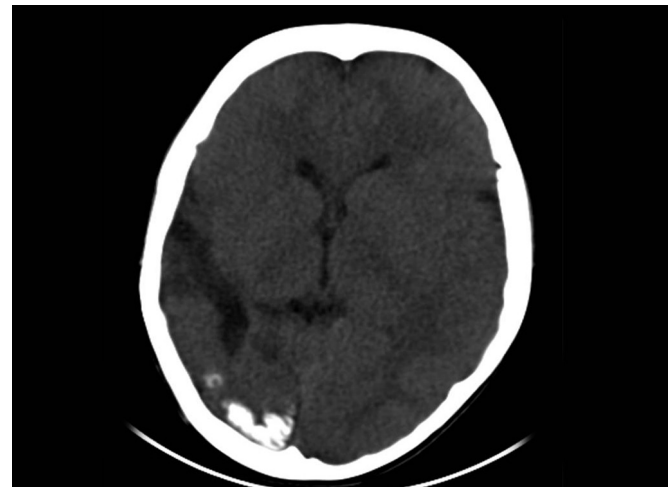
Plain CT brain of a child with Sturge-Weber syndrome (SWS) who underwent right posterior quadrantectomy for refractory epilepsy showing gyriform pattern of calcification over the right occipital lobe
